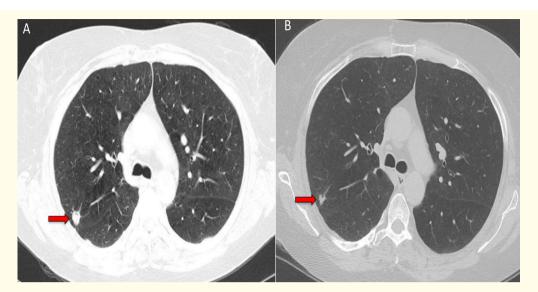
Axial view from the patient #2 CT chest at presentation (A) and three months later (B). Panel A shows a spiculated, and partially cavitated lung nodule (red arrow) in the right upper lobe, measuring 1.3 cm. Panel B shows the same lung nodule but with significant decrease in size, measuring now 0.6 cm (red arrow).
